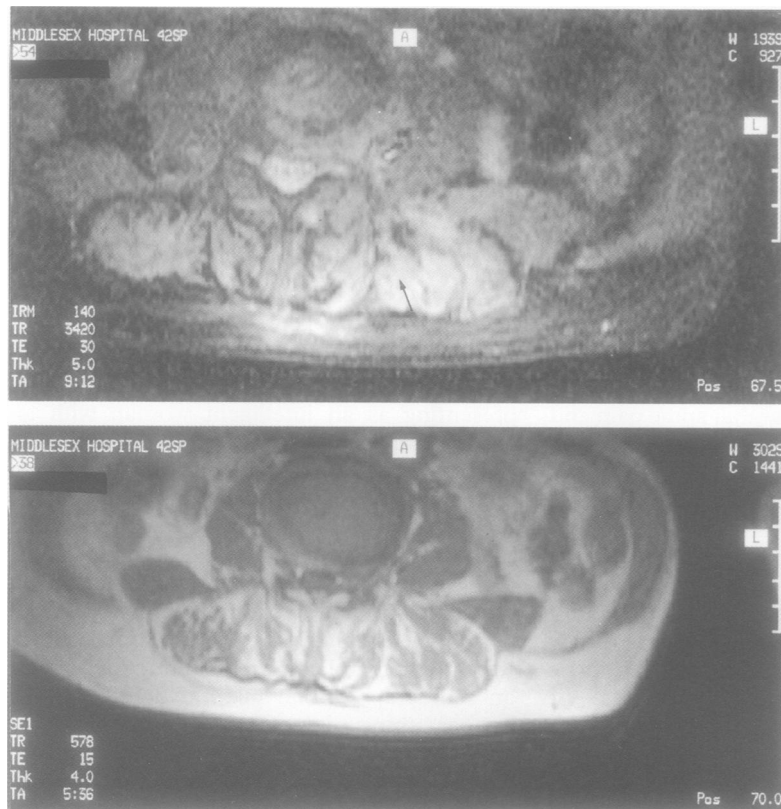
Magnetic resonance imaging scan of thoracolumbar spine showing (top) increase in water content (arrow) and (below) heterogeneity of the paraspinal muscles.
